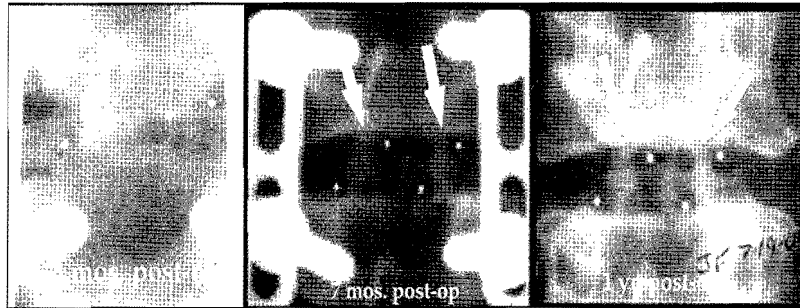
Serial Ferguson views of two 9-mm cages demonstrate progression to excellent fusion at 1 year on radiographs. The bone in the fusion area is radiographically more dense and mature than originally achieved in surgery. There is no interface between the autograft bone and the vertebral bone. Arrows point out bridging bone across the interspace through the fusion cage.
